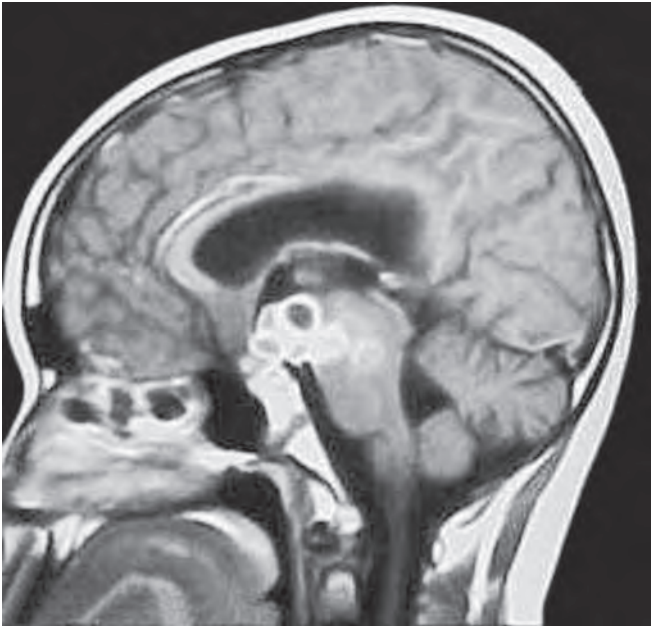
CT scan of tuberculoma brain—grape-like cluster
